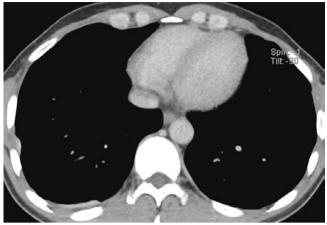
Talc pleurodesis. Axial CT shows hyperdense thickened right posterior pleura in a patient with previous talc pleurodesis for recurrent pneumothorax
